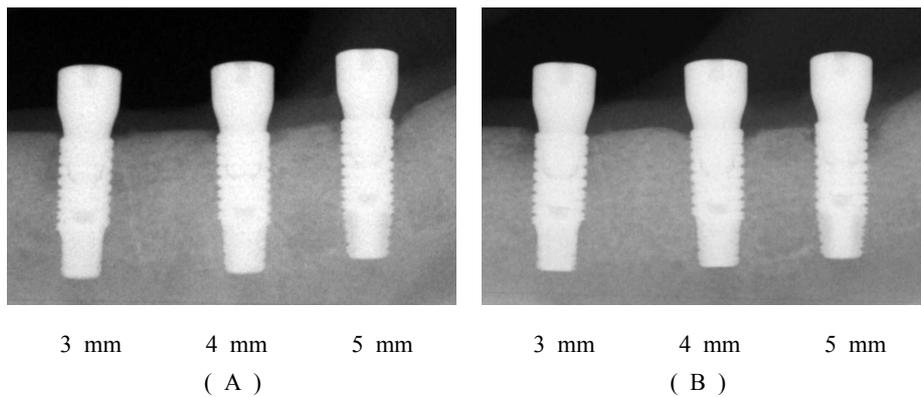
Periapical radiographs taken at 3 weeks (A) and 12 weeks (B) after implant placement.
